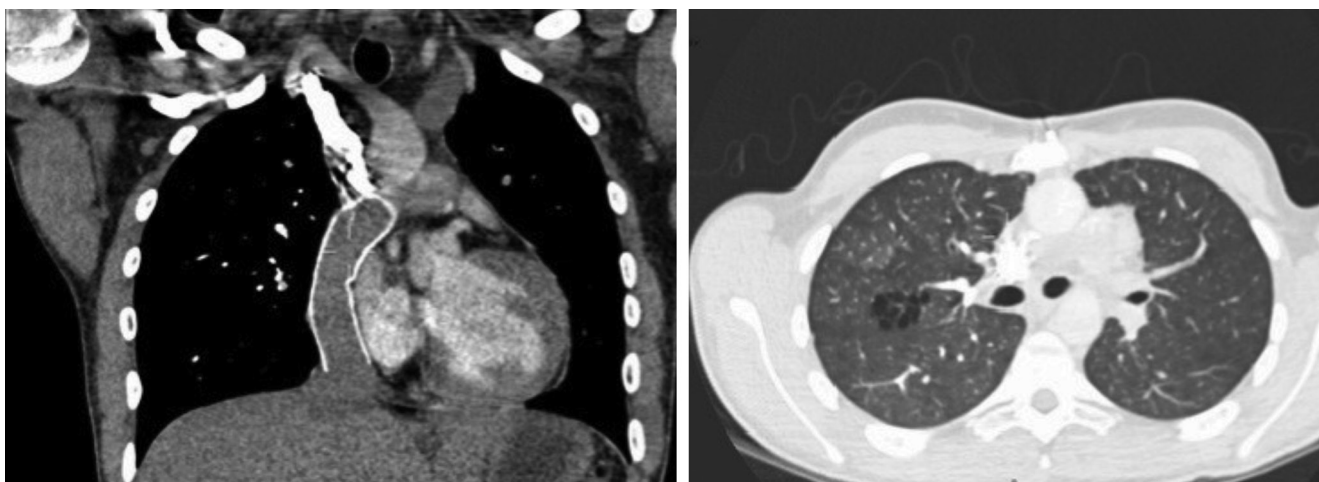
Computed tomography (CT) pulmonary angiogram coronal and transaxial images below the level of the carina. A extra cardiac conduit demonstrated with the superior vena cava (SVC) to pulmonary arteries (PA) and a stent within the intra-thoracic inferior vena cava (IVC) which enters the right PA resulting to single ventricle/Fontan physiology. There is non-opacified blood within the stent as a result of passive venous supply to the lungs in Fontan circulation and IV contrast seen within the stent post upper extremity contrast administration and passive venous supply to the lungs. There is also a hypoplastic right ventricle. The peripheral PA are patent with no evidence of distal PE. There is ground glass shadowing in the right upper lobe with minor cystic changes, which could represent an atypical infection.
